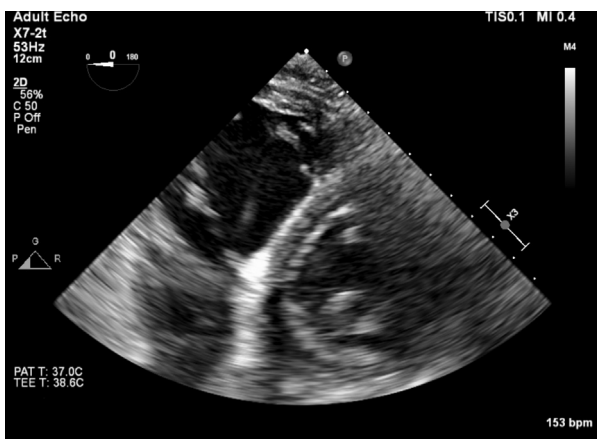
Midesophageal transgastric short-axis transesophageal echocardiography view obtained at end-diastole showing marked right ventricular dilatation.
